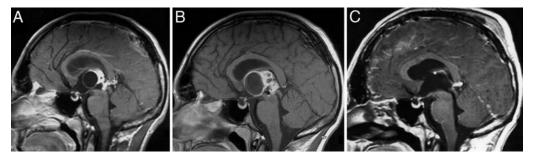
Case 9. Sagittal T1-weighted MR images with Gd enhancement. A: Initial image showing a peripherally enhancing tumor in the pineal region with a large cyst bulging into the third ventricle and a synchronous, small suprasellar contrast-enhanced lesion. Both lesions were identified as germinomas on neuroendoscopic biopsy sampling. B: Image obtained 4 months after diagnosis, demonstrating tumor progression despite 3 cycles of chemotherapy. C: Postoperative MR image showing total surgical removal of the lesion (achieved via a transfrontal transventricular route).
